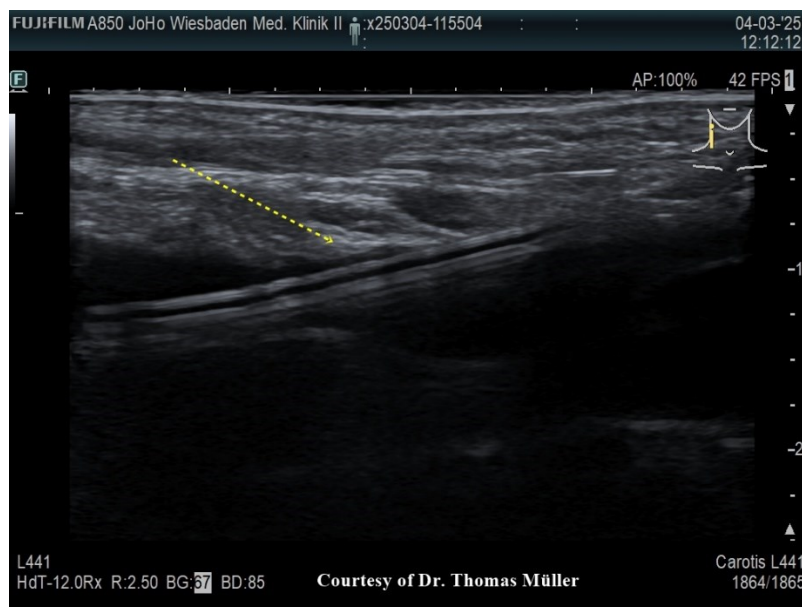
Ultrasound-guided cannulation of the jugular vein with a high-frequency probe. The cannula is visualized in the long axis using the in-plane technique (yellow arrow).
